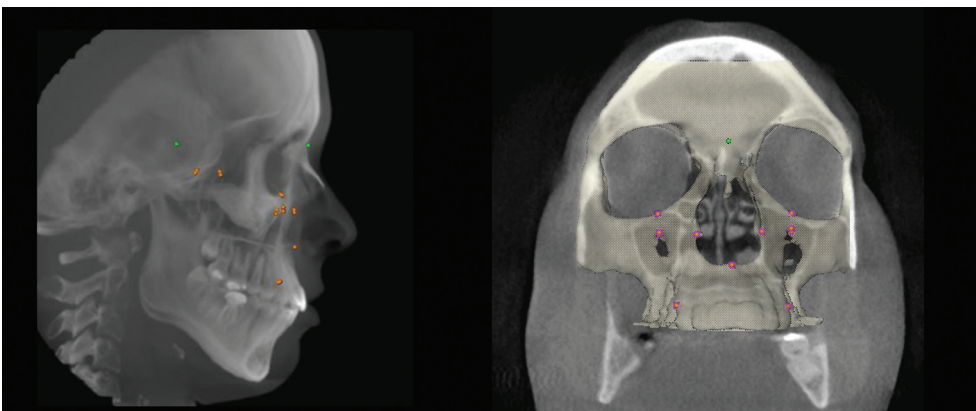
General layout of the Maxilim® software showing hard-tissue segmentation together with radiographic slices in sagittal and coronal CBCT views together with superimposition of 3D skull representations.
